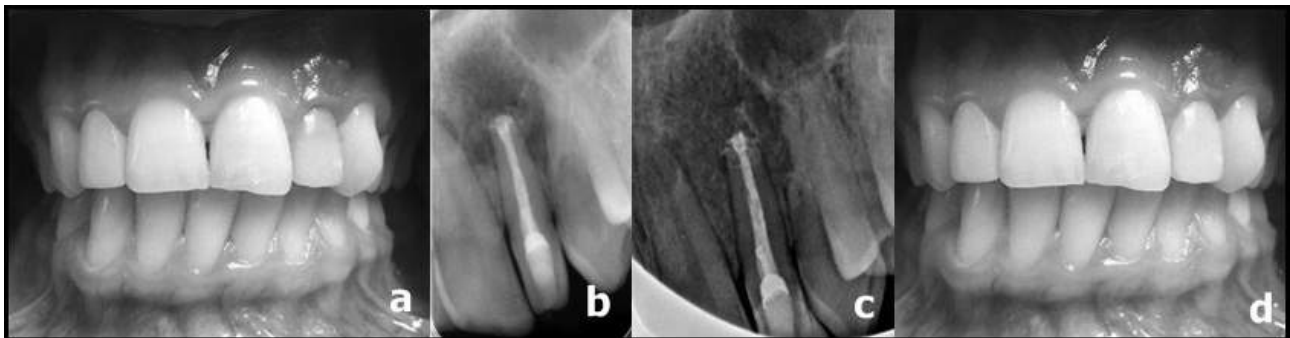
(a) Photograph shows that discoloration of tooth, (b) 6 months follow up with radiographically, (c) 1 year follow up with radiographically, (d) photograph of after bleaching and aesthetic restoration
